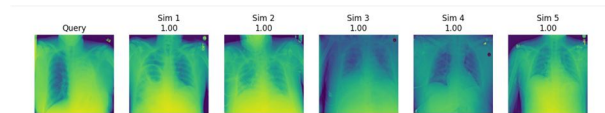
Sample chest X-ray image
